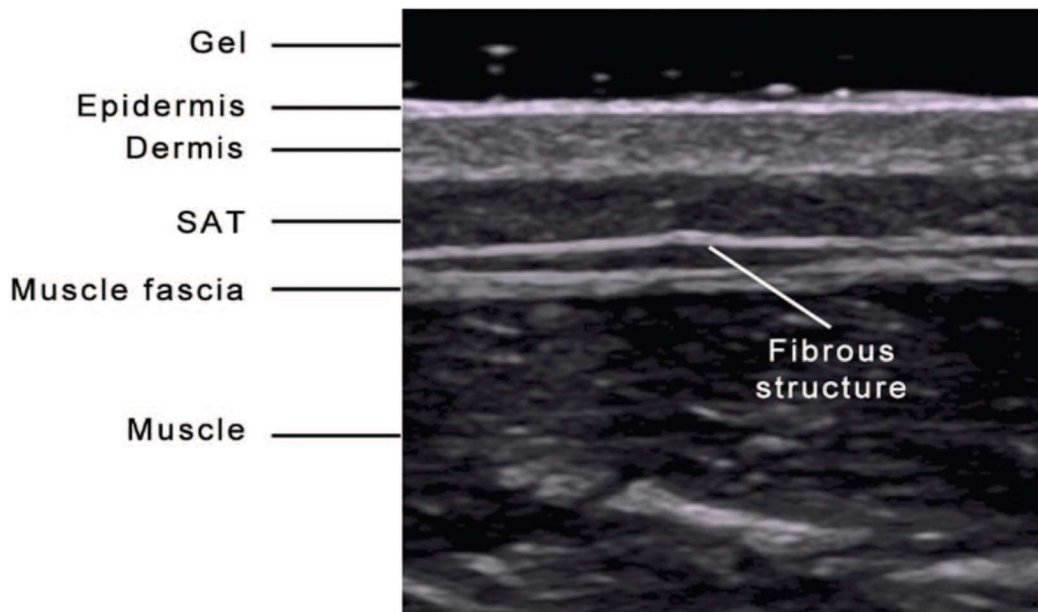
A typical ultrasound image of the subcutaneous fat (Müller et al., 2016)
